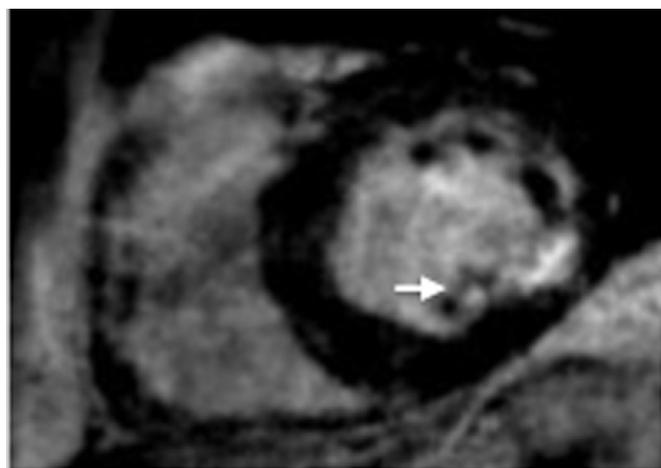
Involvement of the lateral wall as well as posteromedial papillary muscle (arrow) with late gadolinium enhancement on cardiac magnetic resonance imaging, suggestive of scar infiltration into the papillary muscles.
